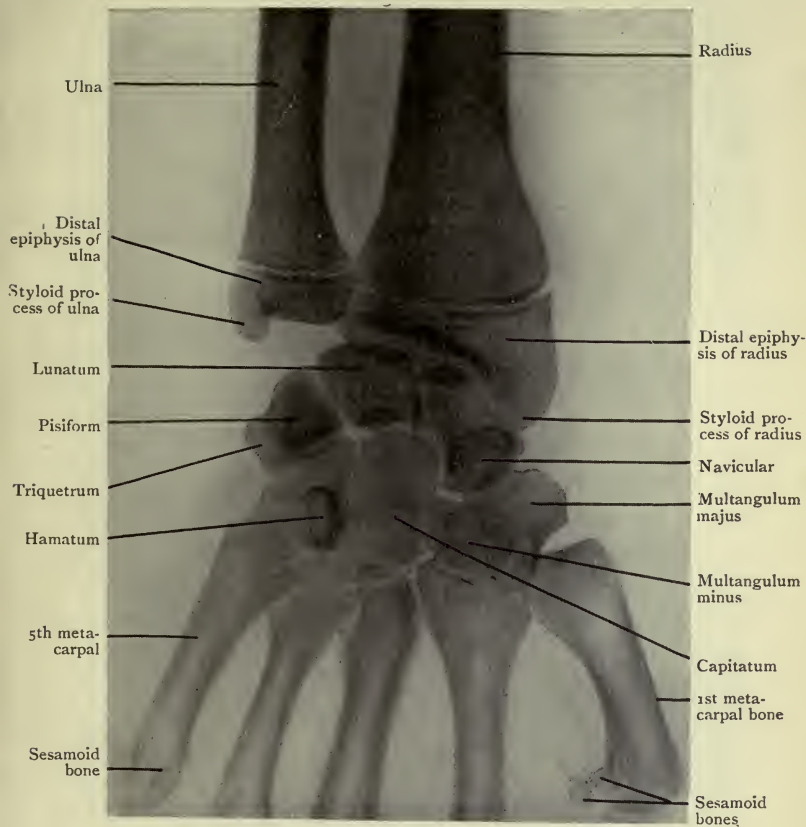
Antero-posterior Radiograph of the Wrist of a Person of 19 years.
